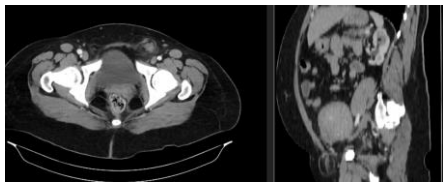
CT scan revealing a sizeable uterine fibroid and a herniated left adnexa with early signs of strangulation
